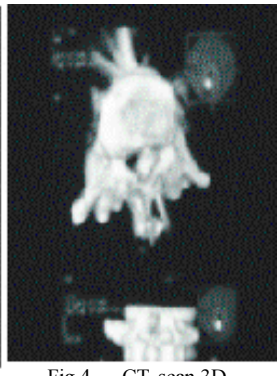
CT, scan 3D reconstruction axial view. Bullet in vertebral canal
